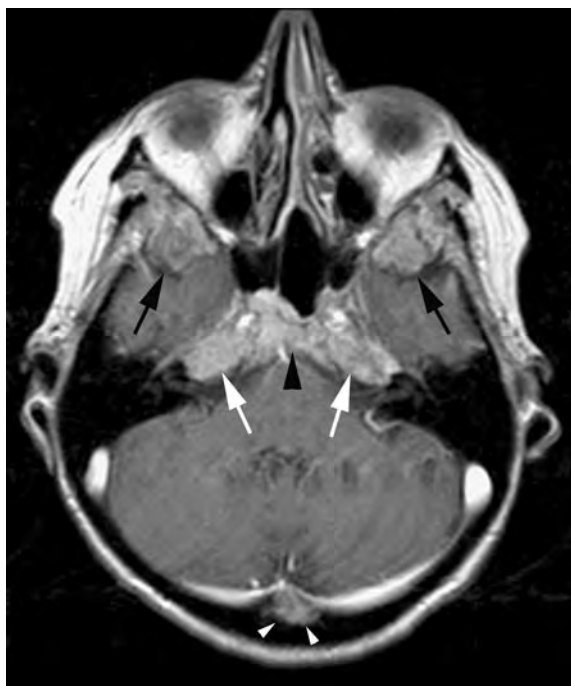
Axial, contrast enhanced T1-weighted image through the upper orbit level shows replacement of the fatty bone marrow with associated bony expansion in the greater sphenoid wings bilaterally (*black arrows*), clivus (*black arrowhead*), petrous apices (*white arrows*) and in the occipital skull (*white arrowheads*) related to multiple myeloma
